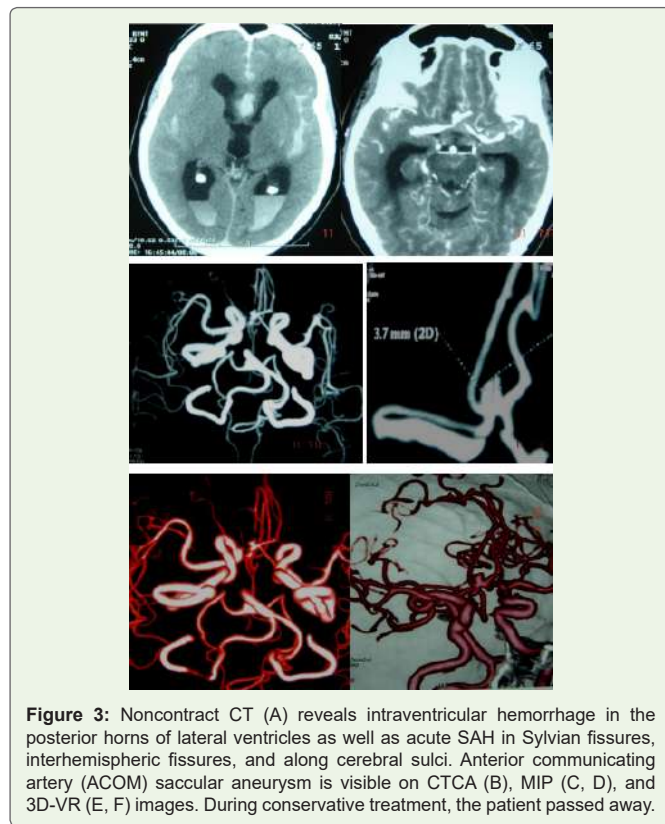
Noncontrast CT (A) reveals intraventricular hemorrhage in the posterior horns of lateral ventricles as well as acute SAH in Sylvian fissures, interhemispheric fissures, and along cerebral sulci. Anterior communicating artery (ACOM) saccular aneurysm is visible on CTCA (B), MIP (C, D), and 3D-VR (E, F) images. During conservative treatment, the patient passed away.
